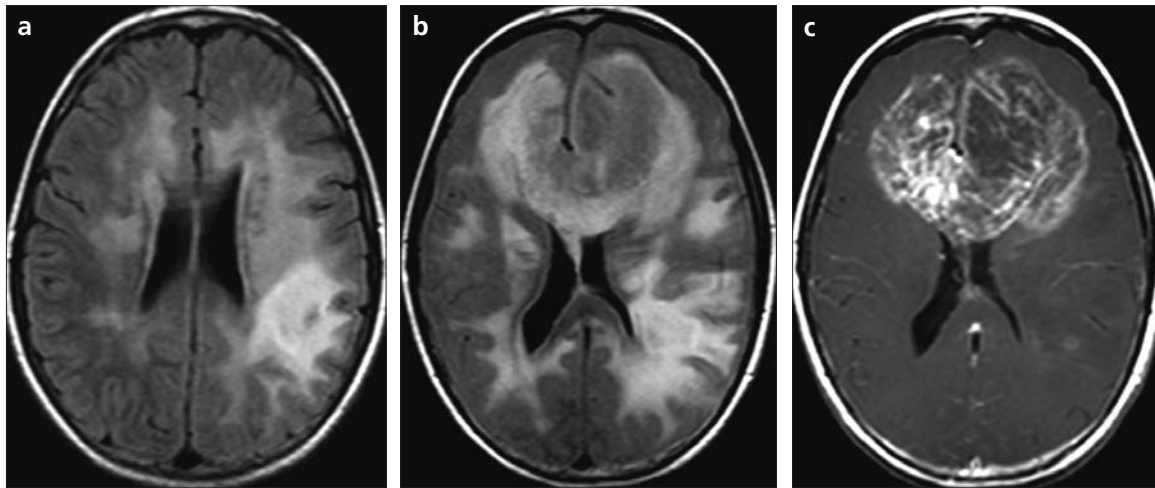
a–c. A 13-year-old girl with acute lymphoblastic leukemia and high grade glial tumor. Cranial MRI shows bilateral frontal, parietal, and occipital hyperintense lesions, containing cystic/necrotic areas in the right parietal lobe on axial fluid attenuated inversion recovery (FLAIR) image (a), diagnosed as radiation necrosis due to the history of cranial irradiation. There was no contrast enhancement of the lesions (not shown). Six months after the first examination, the patient had a contrast-enhancing, irregularly shaped, partially cystic mass in both frontal lobes, infiltrating the body of the corpus callosum, consistent with high grade glial tumor secondary to radiotherapy, seen on axial FLAIR (b) and contrast enhanced T1-weighted (c) images.
